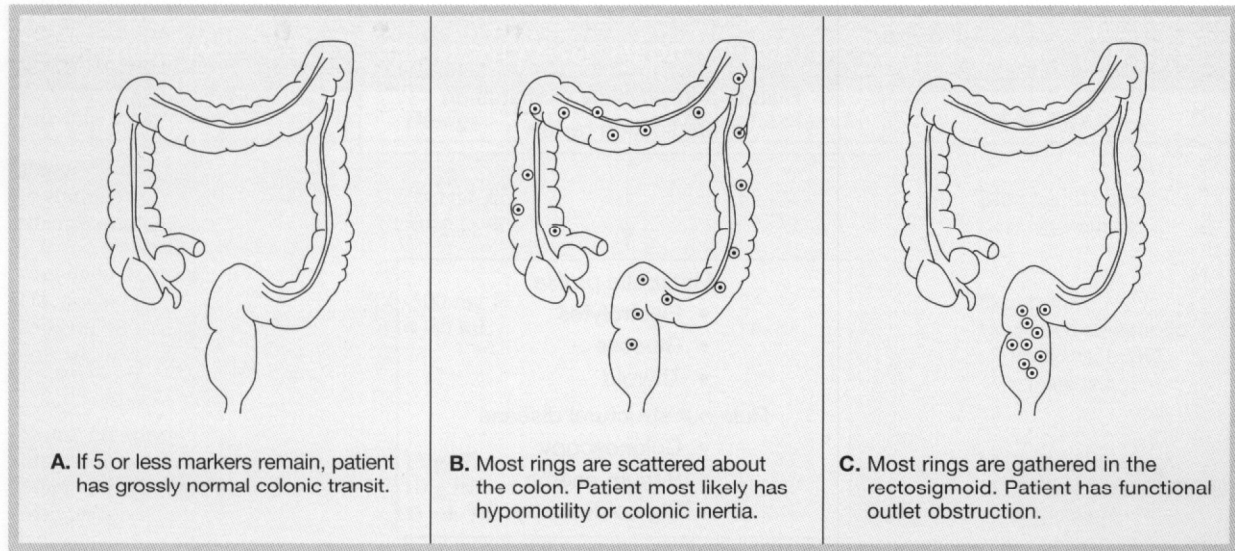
Markers are ingested on Day 0. The patient is instructed to use no laxatives, enemas, or suppositories for 5 days. Abdominal radiographs are obtained on Day 5. The pattern of marker retention helps differentiate between normal (A), colonic hypomotility (B), or a functional outlet obstruction (C). Reprinted with permission from Sitzmarks [brochure]. Fort Worth, Tex: Konsyl Pharmaceuticals, Inc.; 1999.
